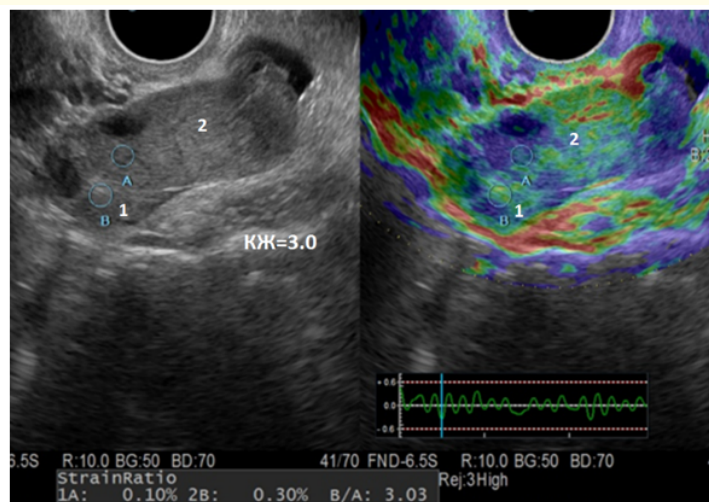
Ultrasound tomography of the tumor of the left ovary patient P diagnosed with highly differentiated endometrioid endometrial adenocarcinoma and moderately differentiated adenocarcinoma of the ovary (compression elastography mode): 1- unaltered ovarian structure; 2- solid formation (tumor).
